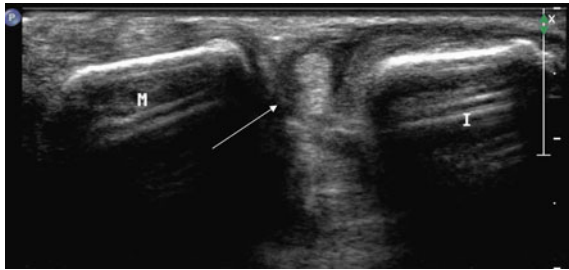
Ultrasound image at MCPJ level shows subluxation of the index finger (I) extensor tendon (white arrow), secondary to extensor hood injury (not shown in this image)
